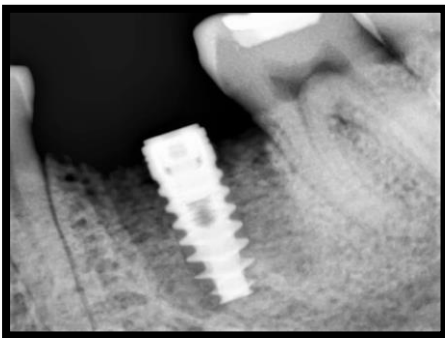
Radiograph after implant placement
